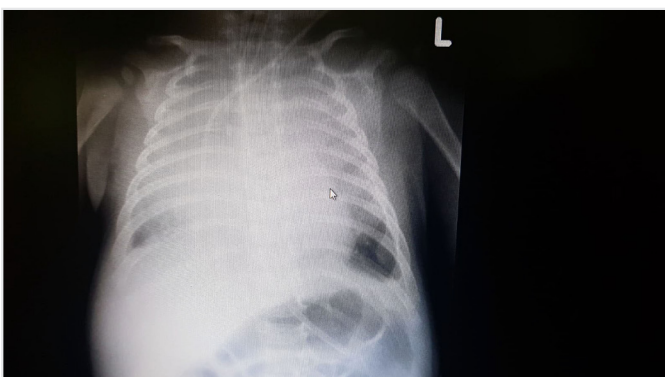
Chest X-ray shows cardiomegaly and bilateral diffuse opacities
